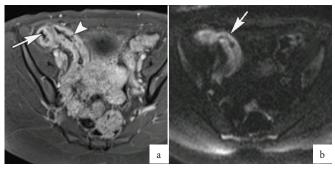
a. Transverse contrast enhanced T1-w image showing an enhancing terminal ileum with mucosal protrusions (arrow) and ulcerations (arrowhead). Same case showing diffusion restriction on DWI as increased signal on high B-value image (arrow).
